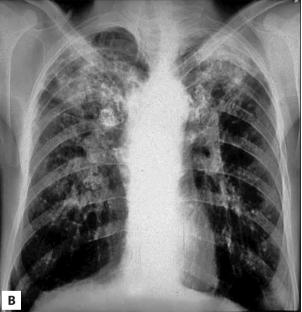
Chest X-ray (PA) of case report 1 patient: A. First hospitalization (1991) – bilateral pleural adhesions and diffuse lung fibrosis with signs of specific lung process; B. Second hospitalization (2002) – bilateral massive irregular, non-homogenous calcified changes in upper and middle parts of lungs
